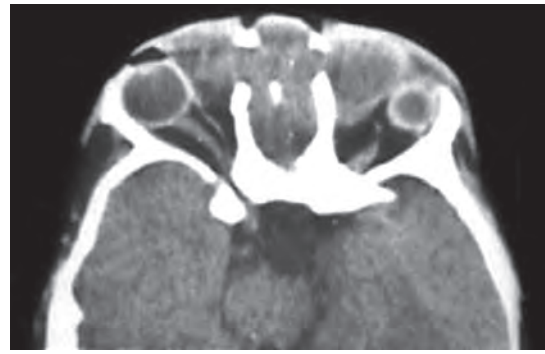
CT scan of a child with bilateral naso-orbital encephalocele showing hypertelorism
